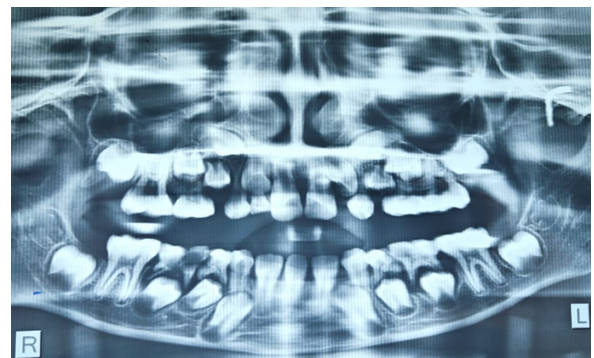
Orthopantomogram (OPG) demonstrating mixed dentition stage without evidence of skeletal pathology in Case 3
